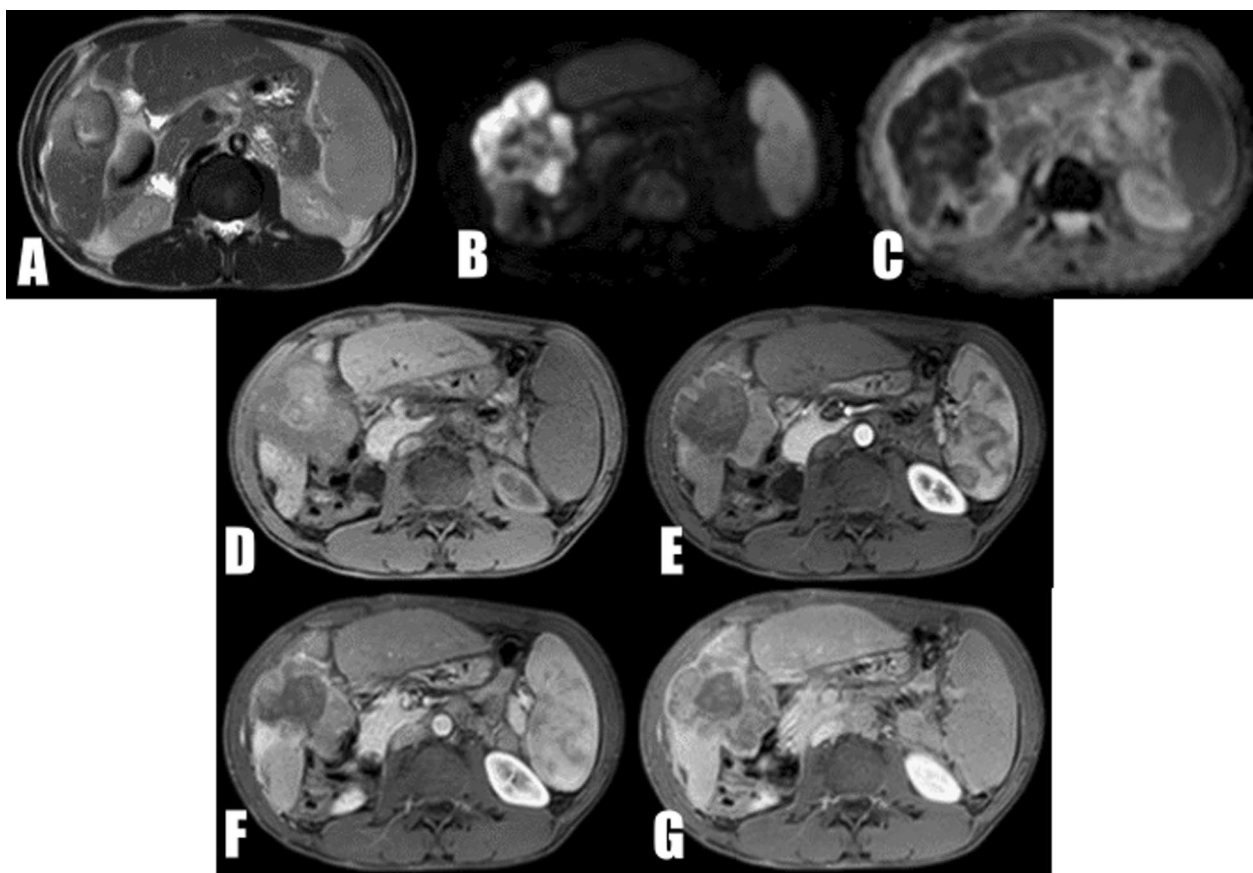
MR imaging of female patient with elevated AFP 2 m after TACE of right liver lobe HCC. A Axial T2 seq. reveals central coagulative and liquefactive necrosis at ablated lesion with peripheral hyperintensity. B & C Diffusion MR study and ADC map reveals restricted diffusion at periphery of ablated lesion denoting malignant viable tumor tissue D–G Dynamic MR study shows no contrast enhancement at periphery of ablated lesion in arterial or portal phases
